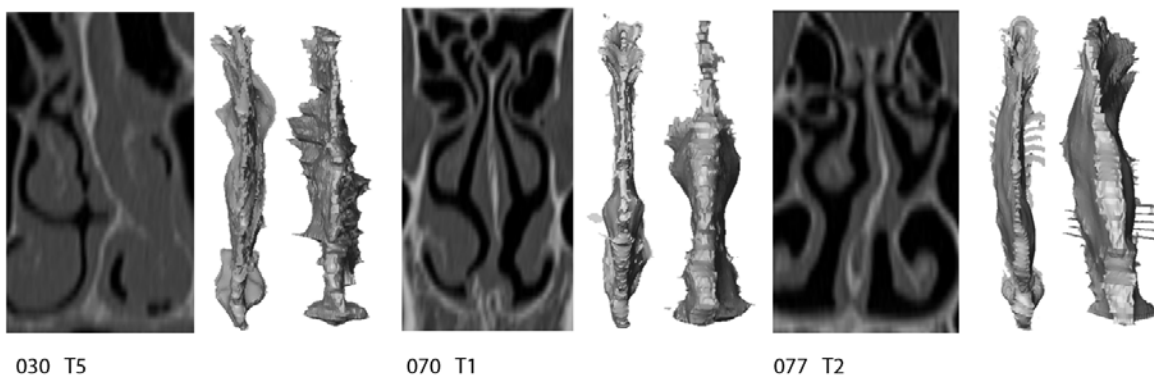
Coronal and axial surface views and axial CT views of T1, T2, and T5 deformities.
